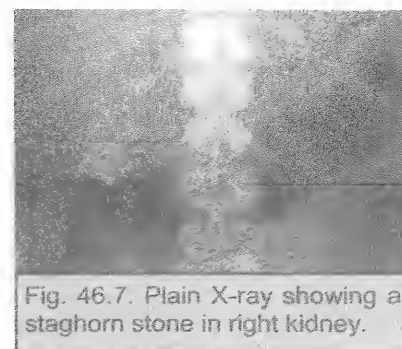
Plain X-ray showing a staghorn stone in right kidney.
